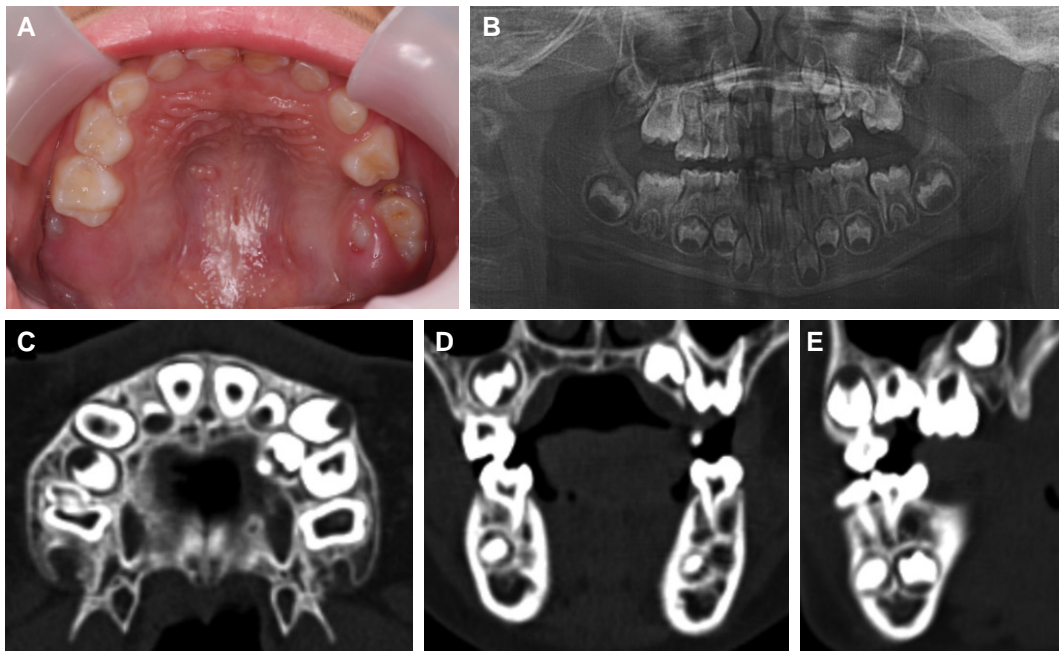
At first examination. (A) intraoral photo. Infraocclusion of the maxillary left second primary molar being covered by the surrounding tissues. (B) Panoramic radiograph. Submerged maxillary left second primary molar with underlying permanent successors. (C-E) CBCT image, horizontal, coronal and sagittal view. Upper left second premolar tooth germ position mesiopalatally.
